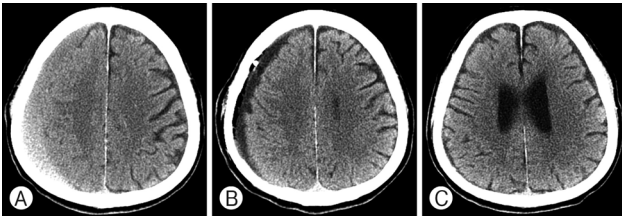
Computed tomography of a 80-year-old male with chronic subdural hematoma treated by burr hole trephination with saline irrigation. (A) Preoperative CT shows chronic subdural hematoma. (B) Immediate-postoperative CT shows diluted residual subdural fluid after irrigation. (C) Postoperative CT 1 month after surgery shows total resolution.
